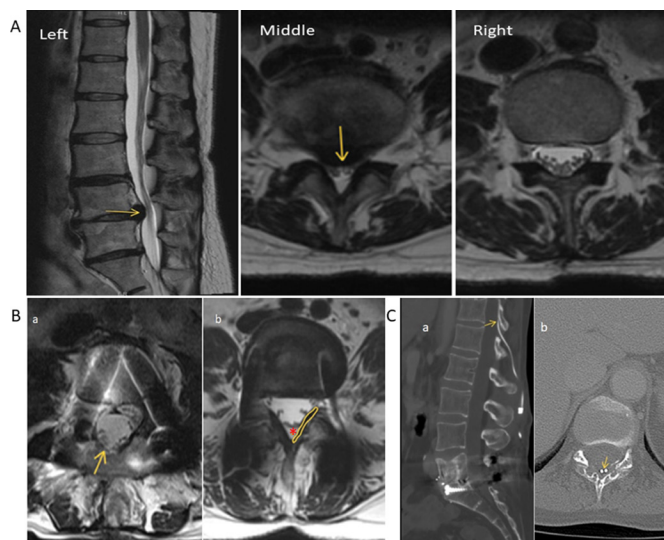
Images of spinal pathology relevant to neuraxial anesthesia. (A) MRI of lumbar intervertebral disc herniation. Left: a T2-weighted MR sagittal image depicting an intervertebral disc herniation at the L4/5 level (yellow arrow) indenting the dural SAC, causing severe central canal stenosis. Middle: a T2-weighted axial view image at L4/5 interlaminar level depicting the same L4/5 intervertebral disc herniation (yellow arrow) causing severe central canal stenosis. Right: a T2-weighted axial view image at L3/4 interlaminar level. (B) MR images of two patients with posterior instrumented spinal fusion through level of hardware. (a) Ligament flavum absent; (b) Intact ligament flavum (left side ligament outlined) and epidural fat (asterisk). (C) CT images of a patient with spinal cord stimulator. (a) Sagittal view SCS lead entering the dorsal epidural space at T12/L1 level (yellow arrow). (b) Axial view dual SCS leads at T12 level (yellow arrow). SCS, spinal cord stimulator.
